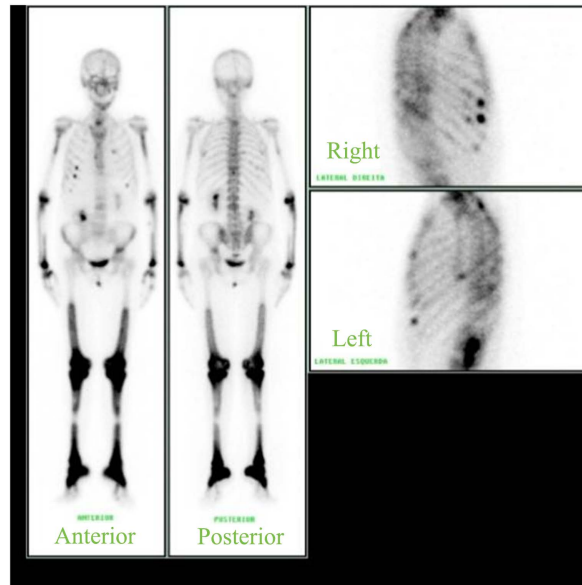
Bone scintigraphy with ^{99m}Tc -MDP showing extensive symmetrical lesions with a marked increase in osteoblastic activity.
